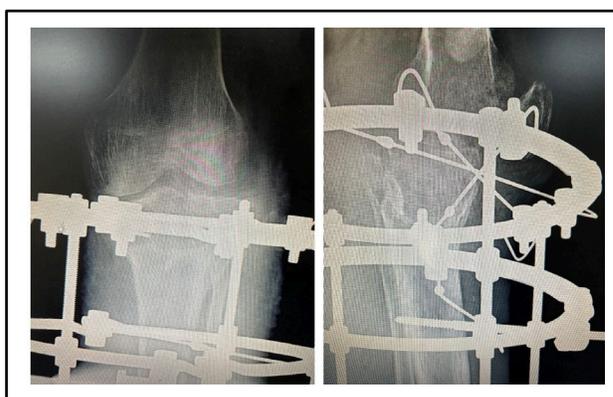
Radiograph post fixation
